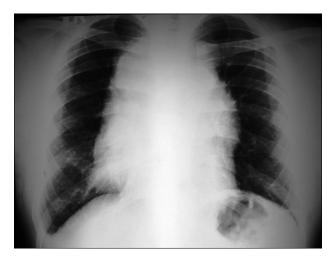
Chest X-ray of patient in arrival day
